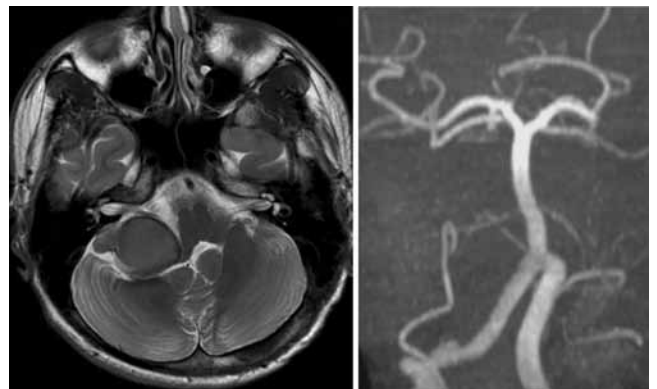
Case 2. Posttreatment MR image (*left*) and MR angiogram (*right*) showing thrombosis of the varix and closure of the fistulous point.
